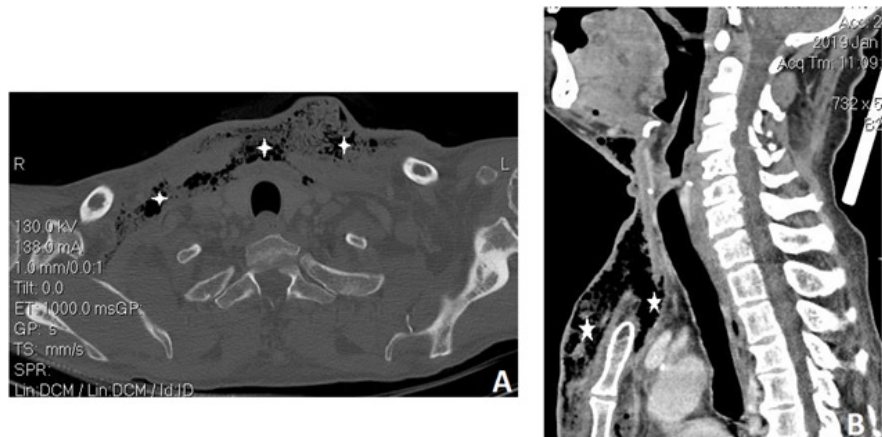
Cervicothoracic CT scan of the patient: (A) = Axial section passing through the cervical region showing air hypodensity indicating soft tissue emphysema; (B) = Sagittal section passing through the cervical and thoracic regions showing air hypodensity indicating emphysema of the pre- and retro-sternal soft tissues.
